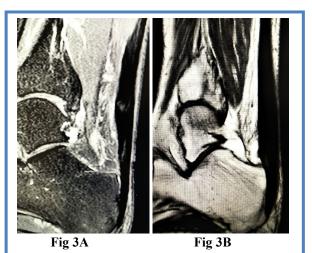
Case C (MRI): sagittal plane): Achilles Tendon Lesion before (3A) and 2 months after (3B) the regenerative intervention (the images are published with the patient's consent).
